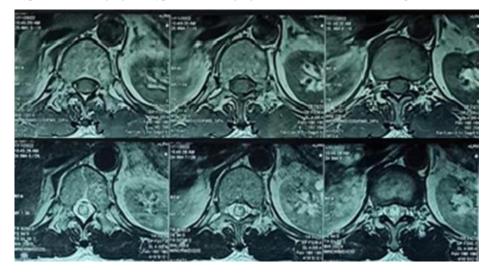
T1 and T2 weighted images of lumbar magnetic resonance imaging (MRI) axial view. T1 weighted images (above); T2 weighted images showed a hyperintense in liquor cerebrospinal (LCS) (below) (Dr Saiful Anwar General Hospital, 2022)
